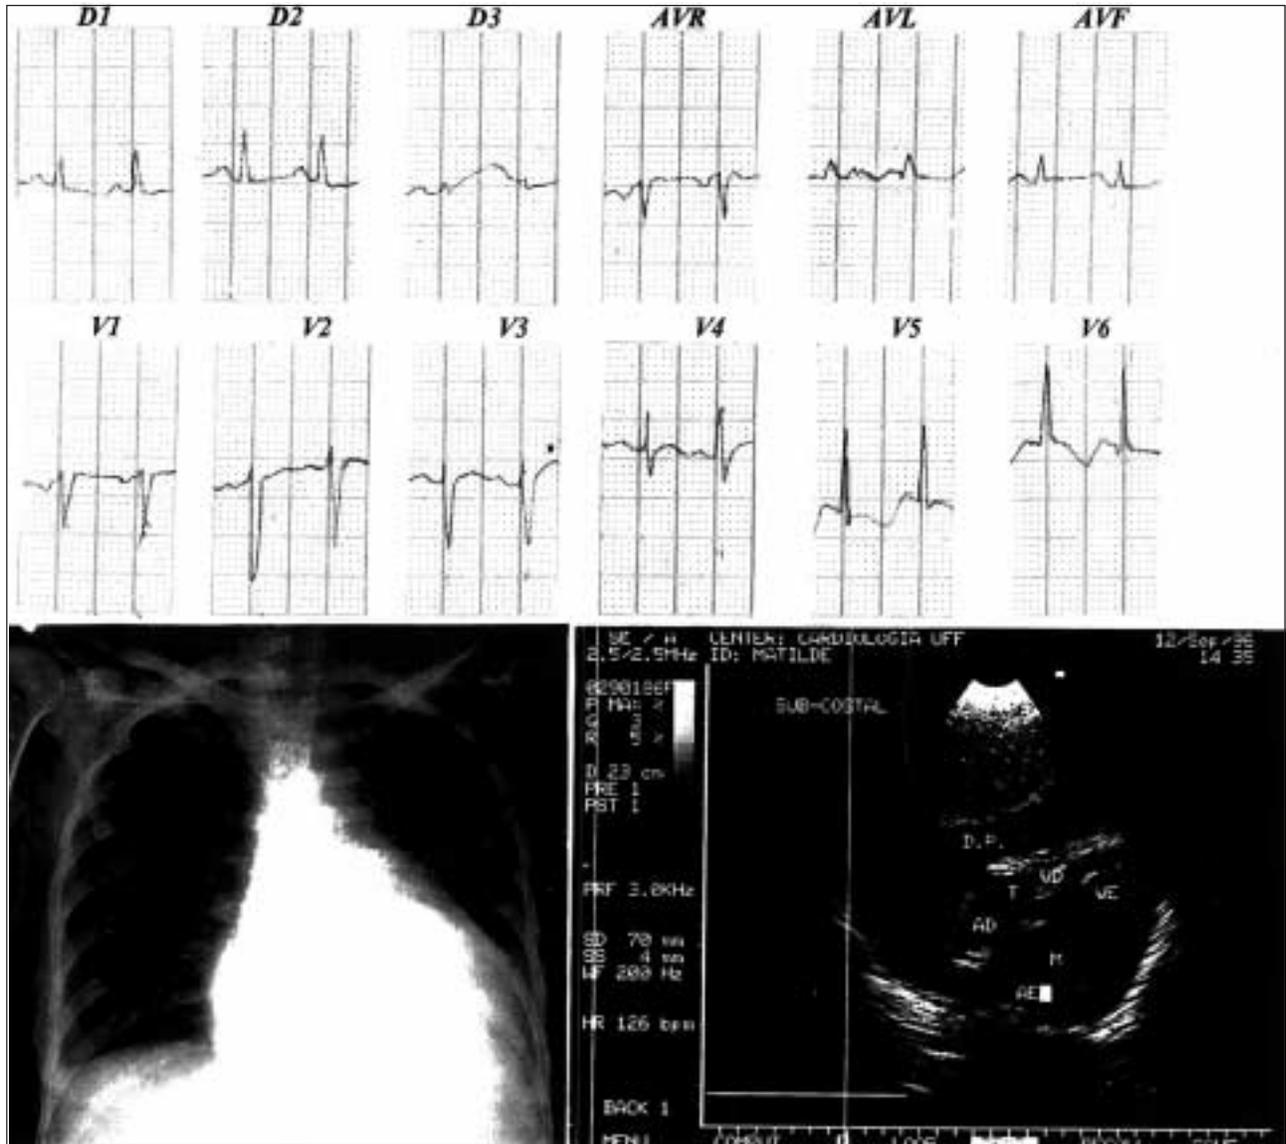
Case 14 – Six months after (close to time of death): severe abnormalities of the ST-T segment, severe increase in the cardiac silhouette due to a large pericardial effusion confirmed by echocardiography.
